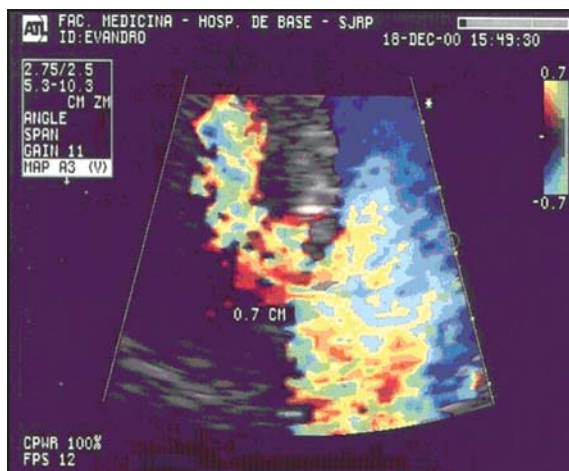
echocardiogram with color flow mapping, demonstrating aorta-right ventricle fistula
